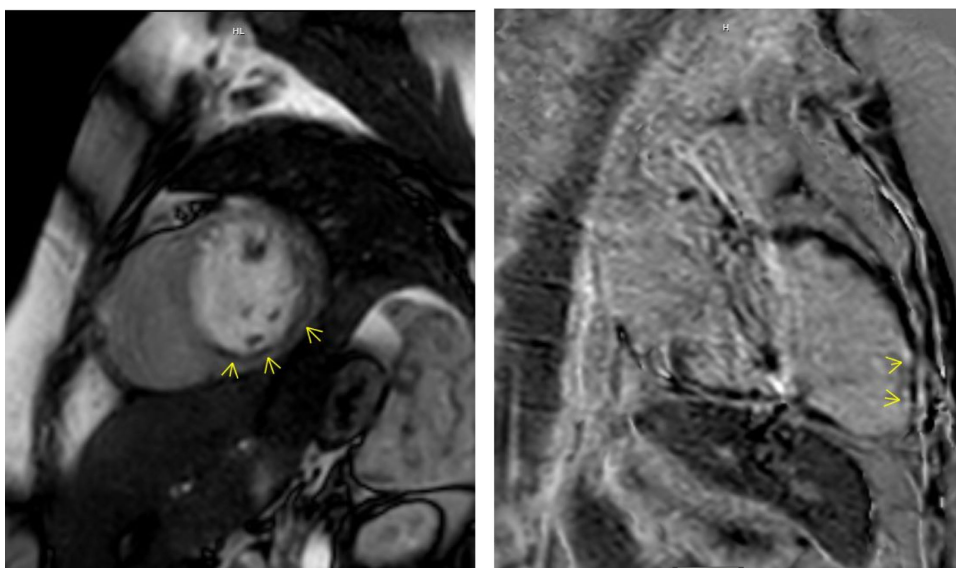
Cardiac MRI from day 2 of hospitalisation demonstrating hypoperfusion on resting first-pass perfusion (left) and multifocal late gadolinium enhancement (right).
